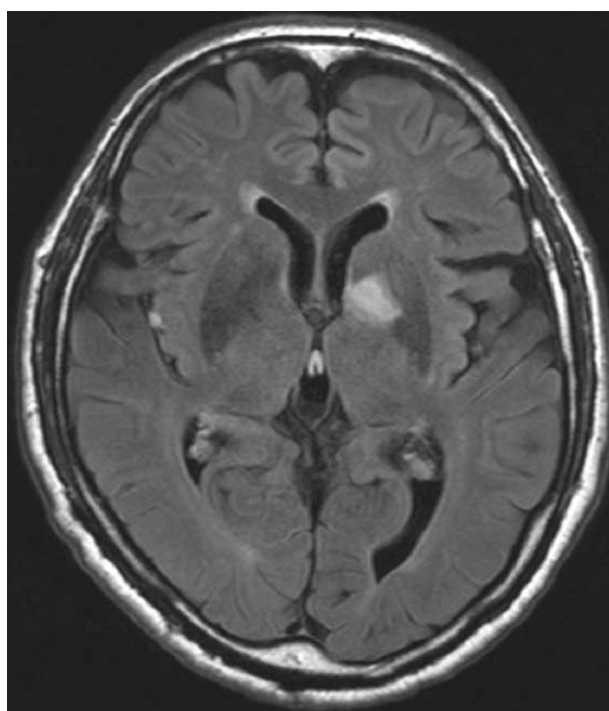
The brain MRI of the patient. The Fluid attenuated inversion recovery axial view shows an infarct involving the left genu of the internal capsule and part of the globus pallidum.
